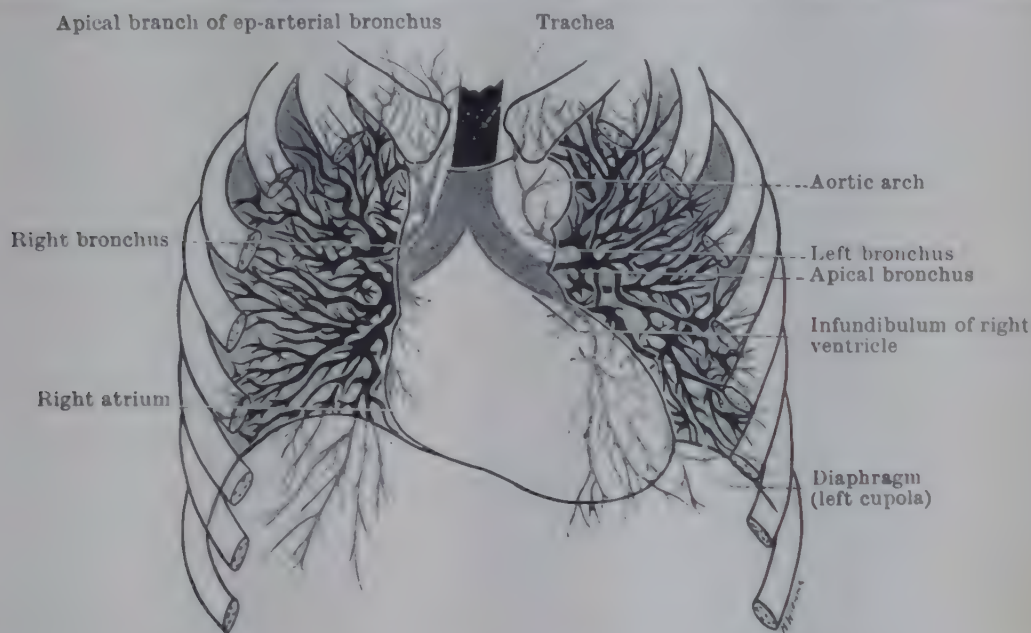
TRACING FROM RADIOGRAPH OF CHEST IN FULL EXPIRATION.
